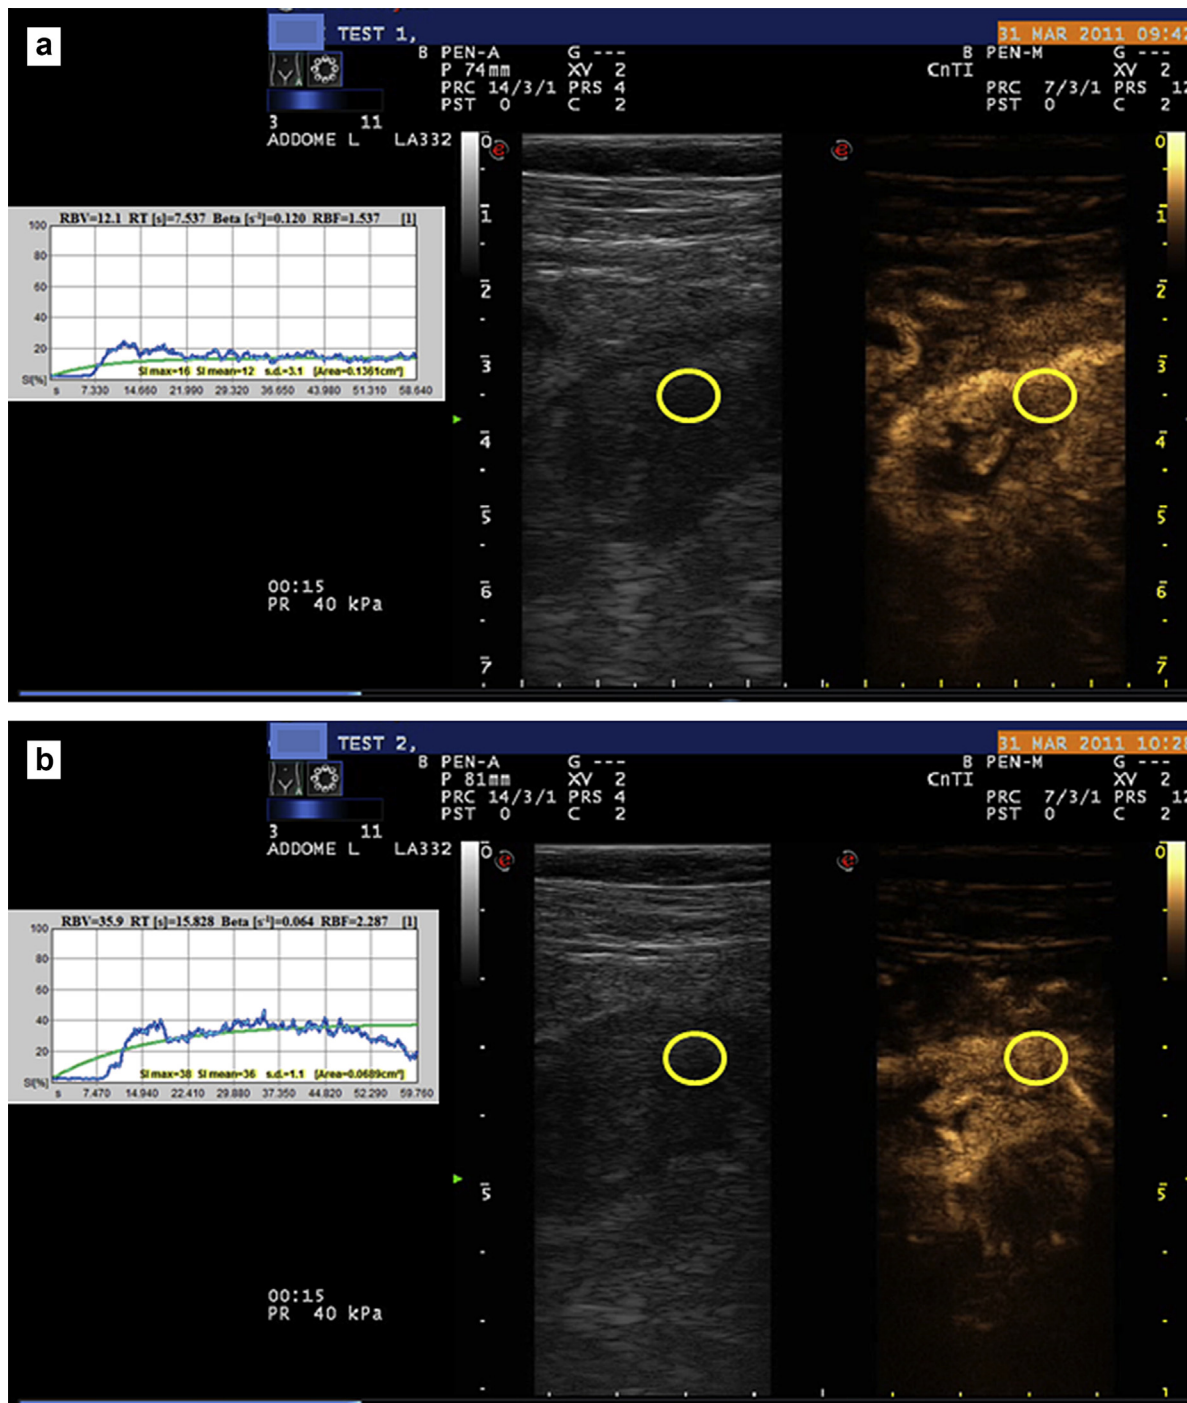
B-Mode and contrast-enhanced ultrasound scan (right) revealing enhancement of the wall of the terminal ileum, and echo signal intensity-versus-time curve (left) within a region of interest, before (a) and 30 min after (b) the standard meal.
